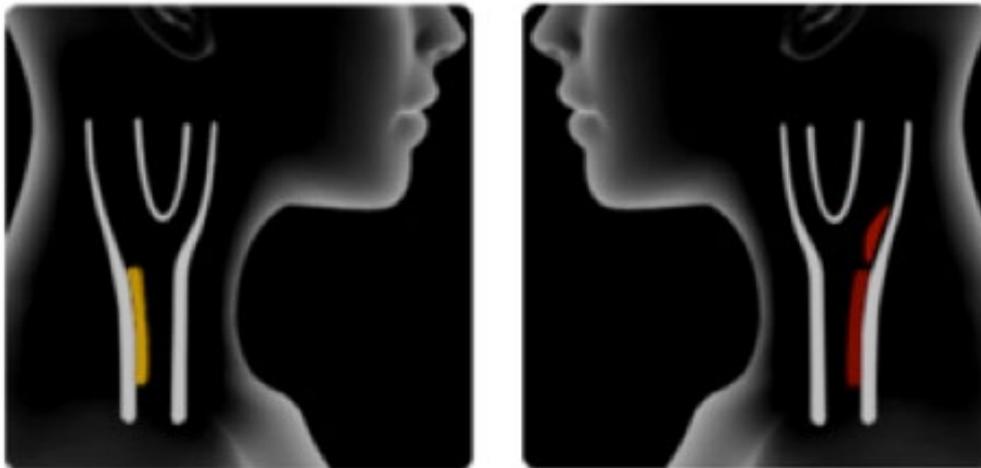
Example of stylised ultrasound images shown to participants in the ViPViZA intervention group.
